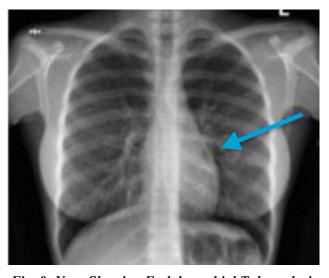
Xray Showing Endobronchial Tuberculosis
